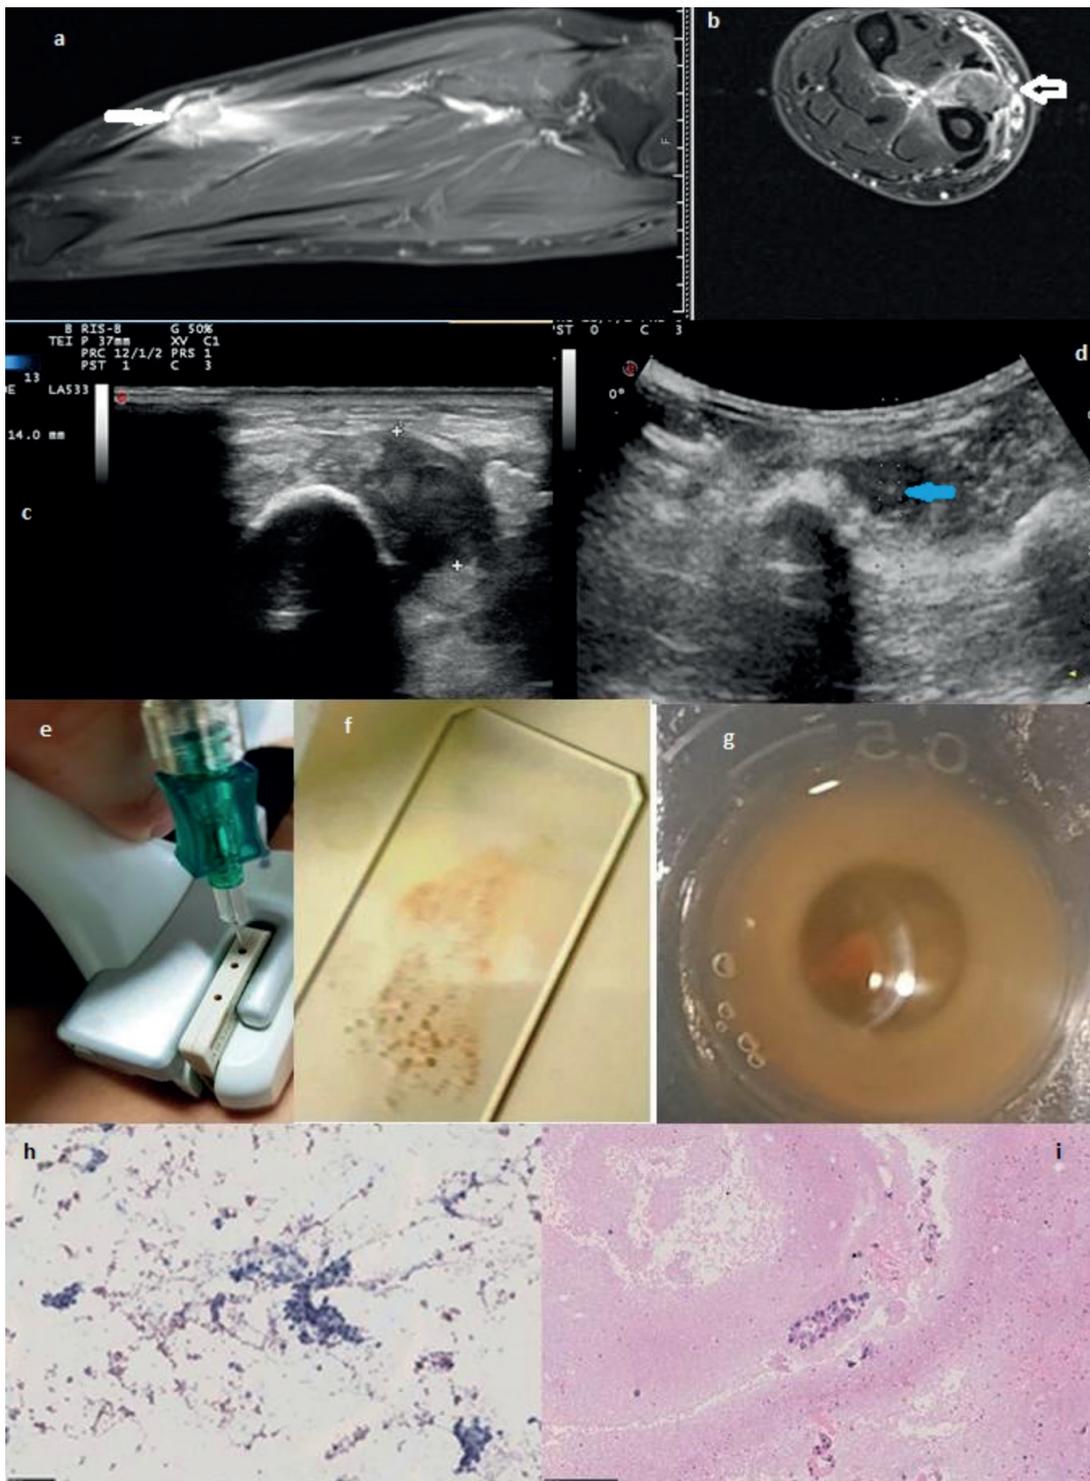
Coronal (A) and axial (B): MRI scan demonstrated a suspected malignant lesion measuring 1.5 cm × 1.0 cm in the context of musculotendinous structures in the posterior compartment of the left distal forearm (extensor fingers) over the dorsum of the hand- wrist-forearm (*white arrow*). Ultrasound scan with linear probe at 12 MHz (C) and dedicated convex probe at 8 MHz (D) of suspected malignant lesion measuring 1.4 cm in the context of musculotendinous structures in the posterior compartment of the left distal forearm (extensor fingers) over the dorsum of the hand- wrist-forearm. E, Ultrasound convex transducers with a central hole for needle passage. F, The sample on the cytology slide. G, Cytological sample for Cell Block preparation; Low power smear magnification (H) shows clusters of neoplastic cells whereas, on high power cell block magnification (I), acinar features favoring adenocarcinoma are observed.
